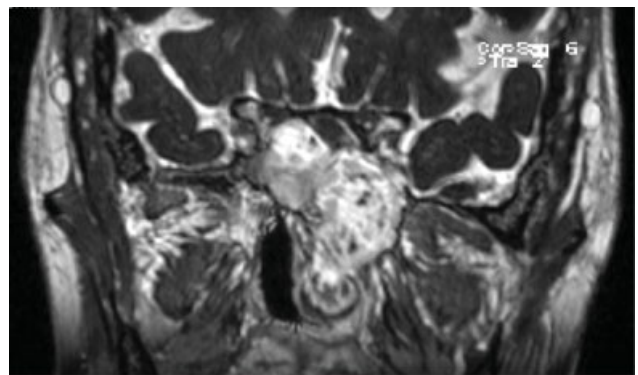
T1-weighted (a) axial and (b) coronal postcontrast MRI demonstrating destructive, hyperintense sinonasal lesion with left cavernous involvement and partial encasement of left internal carotid artery.
